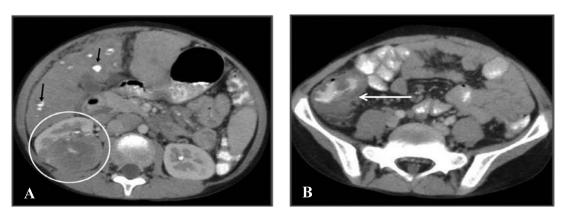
Renal involvement in a 9 year old boy diagnosed with abdominal TB. Fig. 5 A demonstrates abnormal appearance at the posterior aspect of the right kidney with a large nodule of mass-like configuration (encircled). Note that the liver demonstrates numerous small calcifications (small black arrows). Fig. 5 B is an axial CT scan image of the lower abdomen from the same patient demonstrating a significantly thickened wall of the cecum (arrow).
